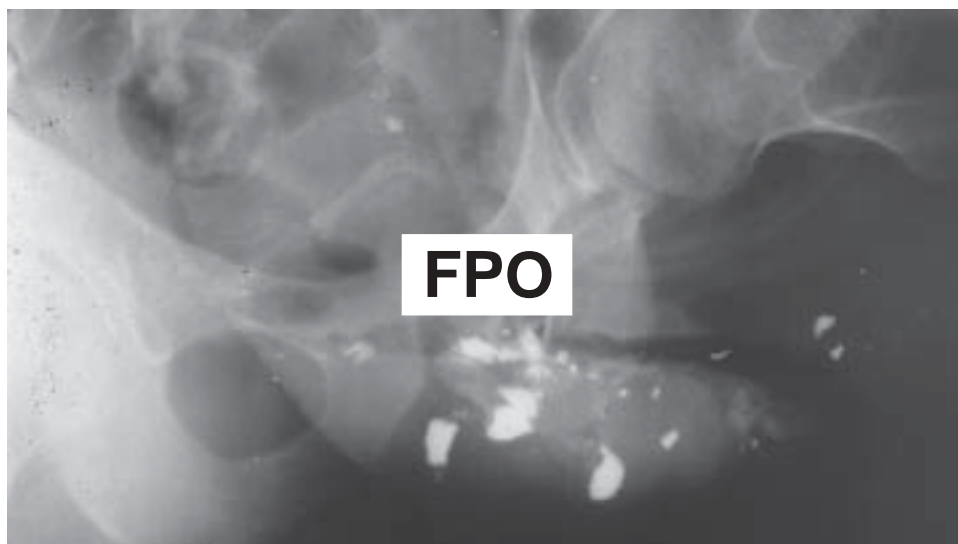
Case 9-1. The patient was a helicopter pilot during the Vietnam War. The roentgenogram shows multiple missile fragments from the metal seat of the helicopter, involving the soft tissues of the genitoperineal region.
